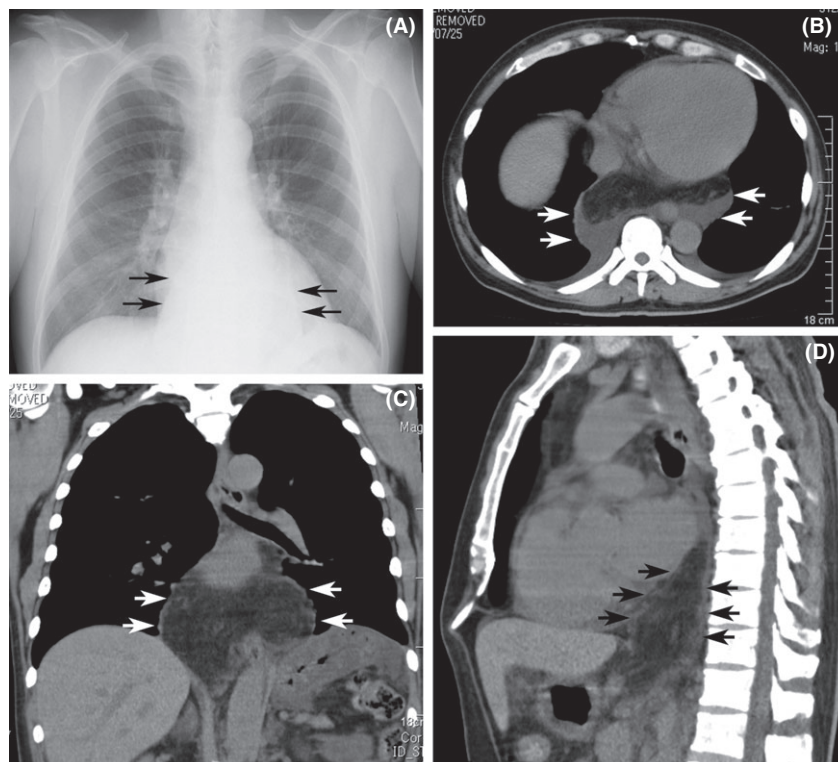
Radiograph and computed tomography (CT) scans of a 46-year-old man with omental herniation through the esophageal hiatus. A, Chest X-ray shows a large and sharply defined retrocardiac mass (arrows). B, Axial view of CT scan shows a large fat density mass in the posterior mediastinum (arrow). C, D, Sagittal and coronal views of CT scan show a fat density mass extending from the abdominal cavity to the mediastinum (arrow).
